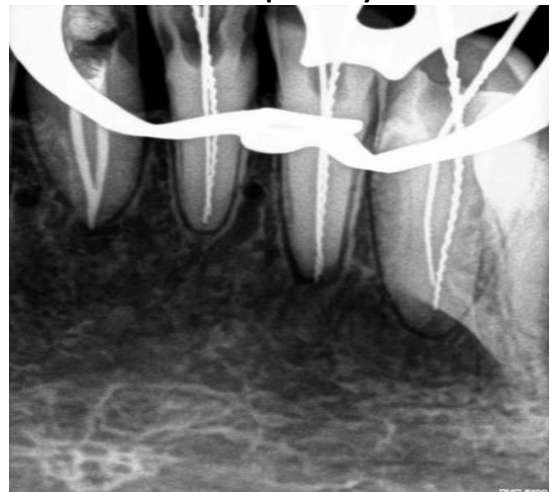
Working Length Radiograph Of 41, 42 And 43 Respectively
